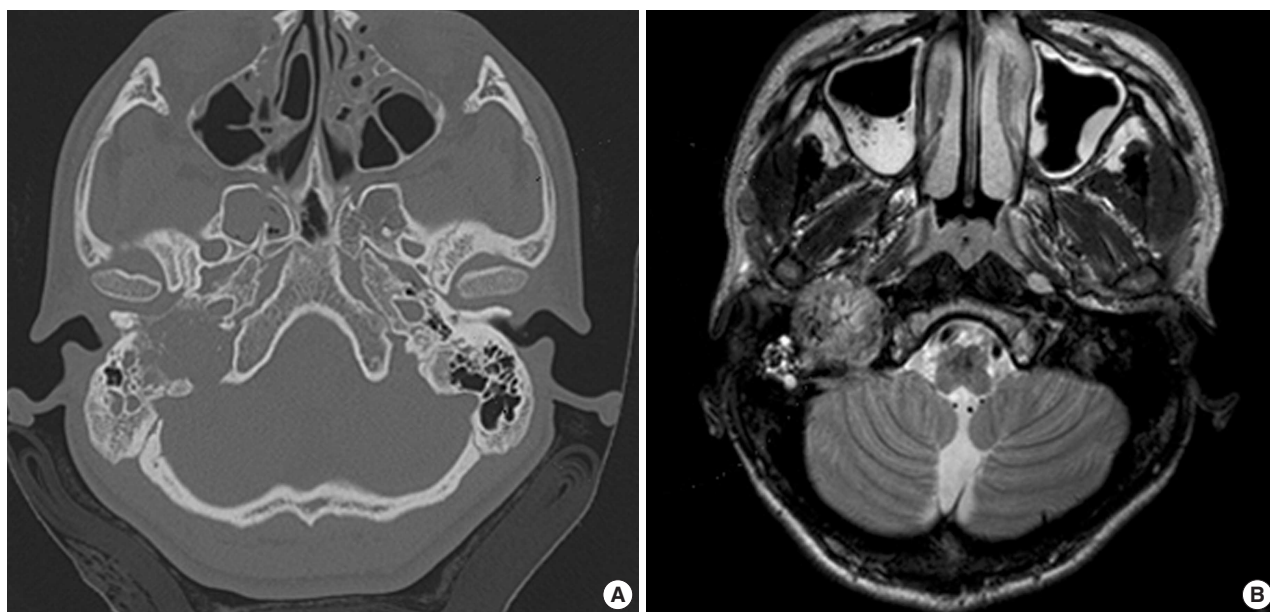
(A) Computed tomography shows a destructive lesion of the right temporal mastoid process and the middle ear cavity having communication with the right external auditory canal. (B) T2-weighted magnetic resonance image shows a mildly high signal intensity middle ear mass that extends to the right mastoid air-cell and petrous apex area with encasement of the right internal carotid artery.
